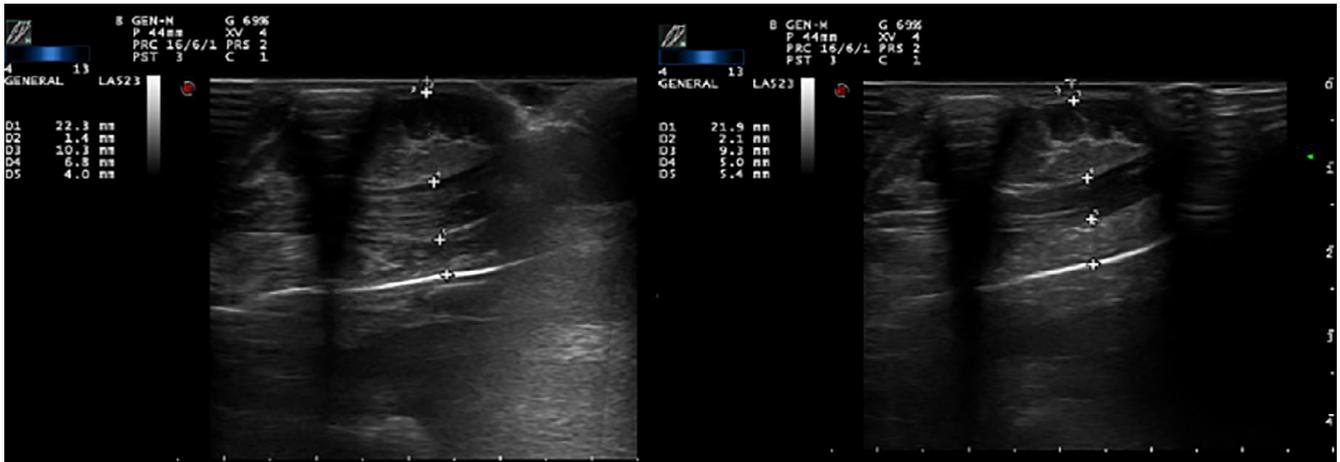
Right hand in the prone position at the time of admission (left) and discharge (right), respectively. Doppler ultrasound at the time of admission (left) and discharge (right). Measures show from the surface to the deepest layer: skin subcutaneous fat dorsal, dorsal interosseous muscle, adductor pollicis muscle dorsal of the first finger, and palmar skin subcutaneous fat. An increase in fat mass and skin is observed, but not in both muscles.
